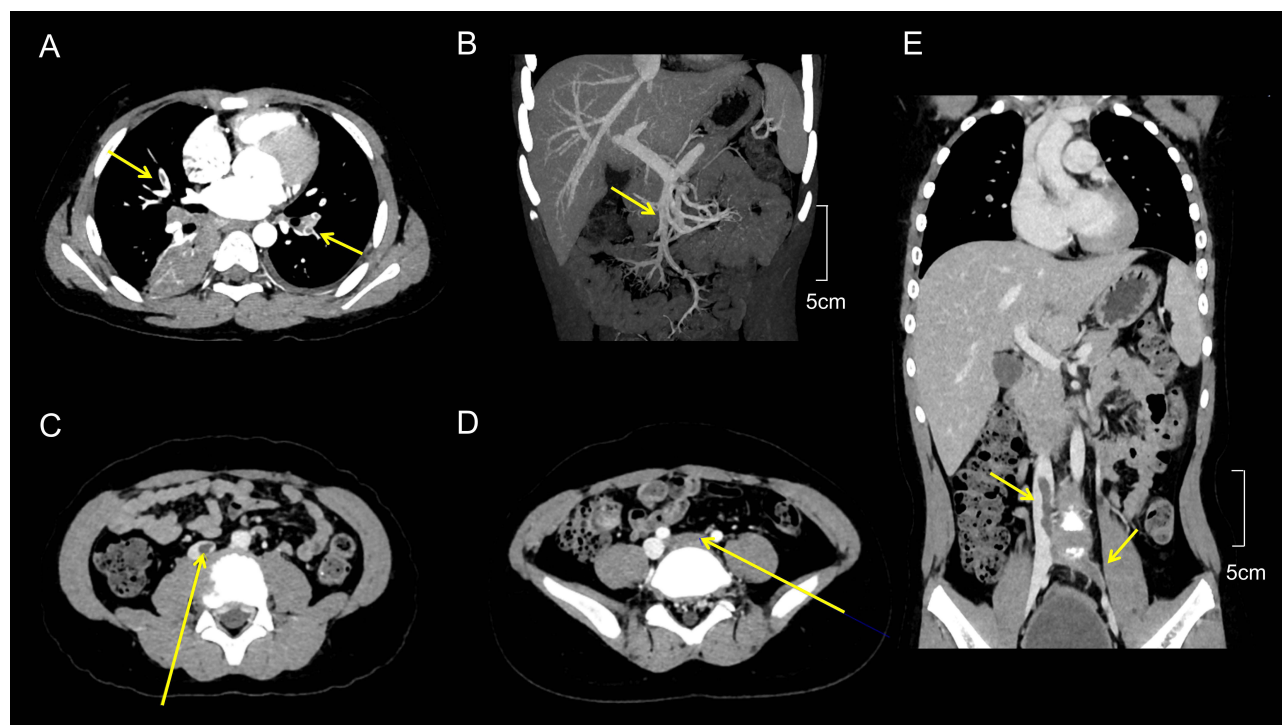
The computed tomography angiography reveals the thrombi in the left and right pulmonary arteries (A), mesenteric vein (B), inferior vena cava (C), and left common iliac vein (D). The thrombi in the inferior vena cava and left common iliac vein, measuring approximately 4 cm and 4.5 cm in length, respectively, are visible in the coronal plane (E). The yellow arrows indicate the locations of the thrombi.
